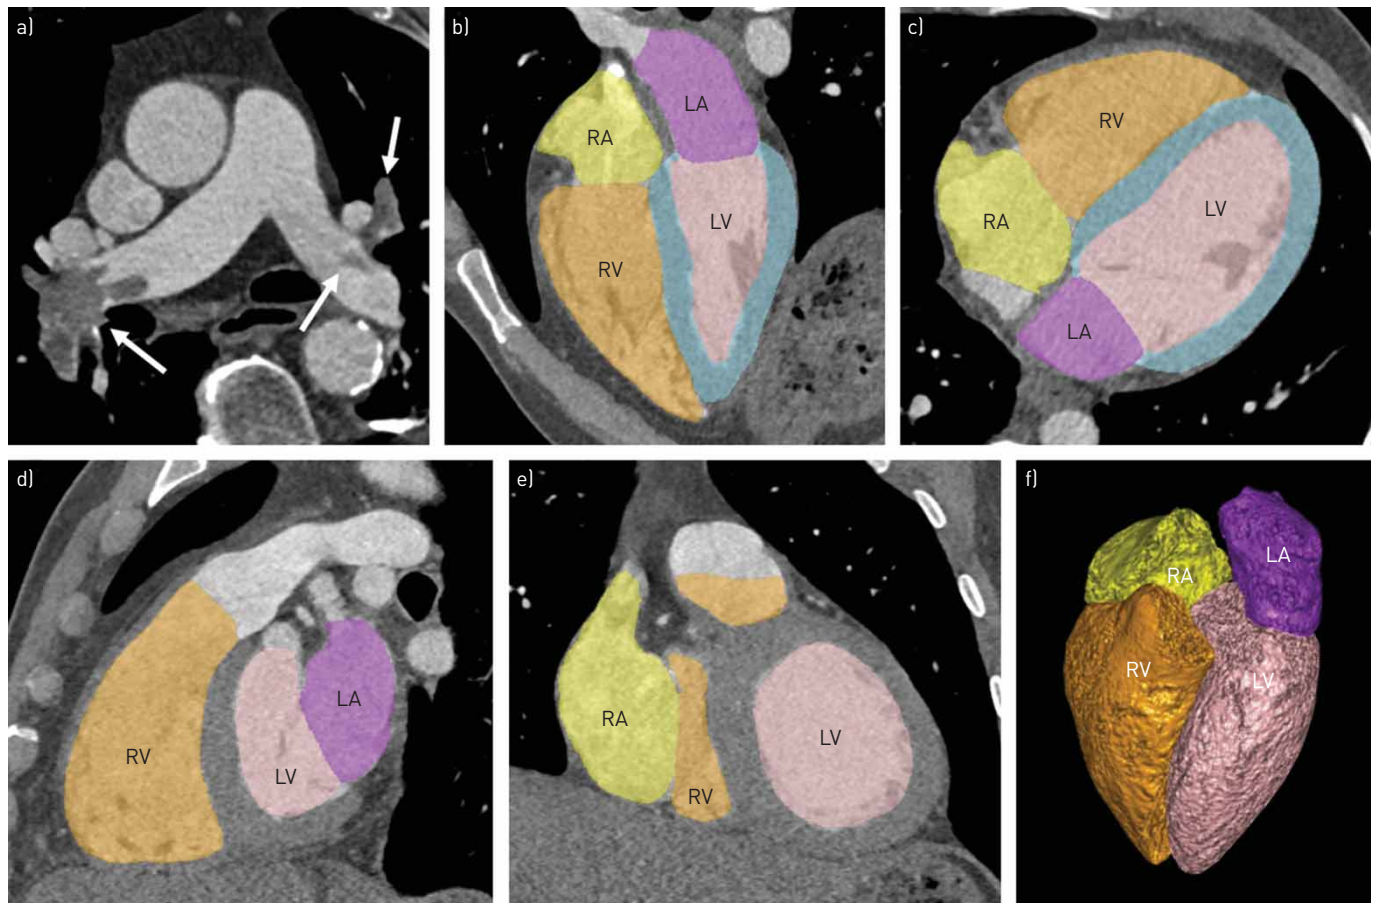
Representative case of volumetric analysis using computed tomography pulmonary angiography. A 35-year-old male patient without relevant comorbidities presenting with dyspnoea, haemoptysis and chest pain (heart rate 92 beats·min⁻¹, blood pressure 155/70 mmHg, respiratory rate 12 breaths·min⁻¹, oxygen saturation 99%) and normal biomarker plasma concentrations (mid-regional pro-atrial natriuretic peptide 84 pmol·L⁻¹, N-terminal pro-B-type natriuretic peptide 35 pg·mL⁻¹ and high-sensitivity troponin T <5 pg·mL⁻¹). The patient was treated with low molecular weight heparin followed by rivaroxaban and discharged after 4 days without suffering any relevant complications. a) Central thrombus in the right (and left) pulmonary artery and thrombus in left segmental pulmonary artery (marked with arrows). b, c) Automated reconstructed b) four-chamber and c) axial view with coloured overlay: right atrium (RA) 92 mL (yellow), left atrium (LA) 75 mL (purple), RA/LA volume ratio 1.23, right ventricle (RV) 233 mL (orange), left ventricle (LV) 203 mL (pink), myocardium (light blue). d, e) Automated d) sagittal and e) coronal multiplanar reconstruction. f) 3D volumetric model of the four cardiac chambers.
